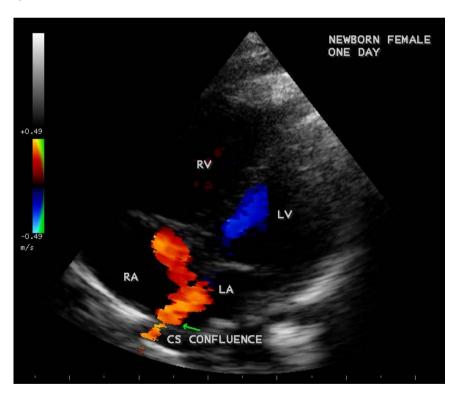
Tilted apical view showing the drainage of CS confluence into Left atrium (LA) in apical four chamber view in a newborn.
